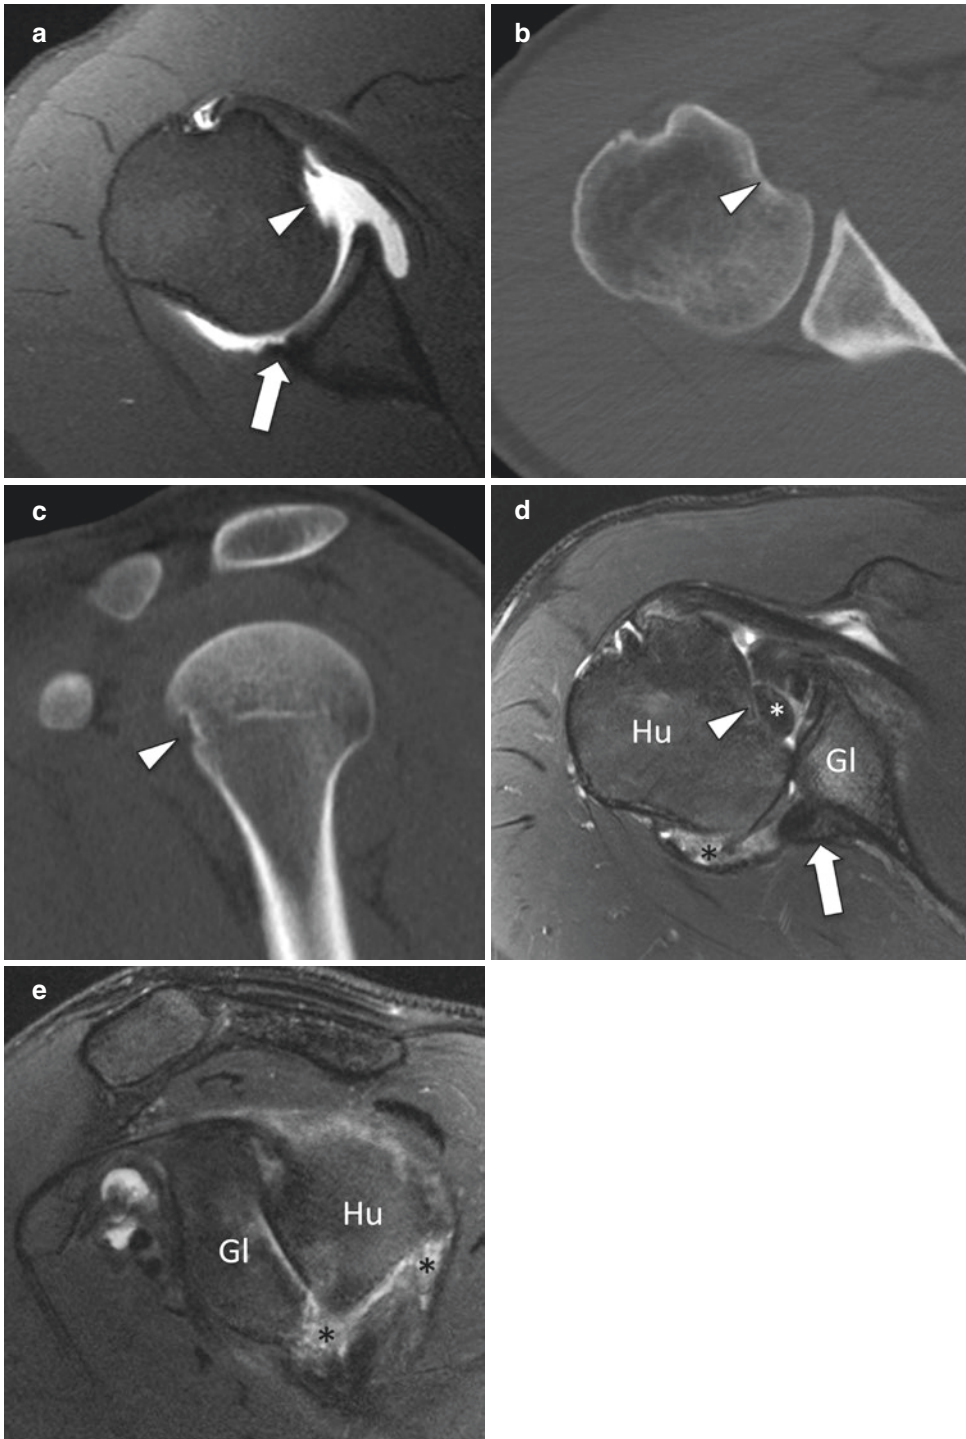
Posterior glenohumeral dislocation. Axial fat-saturated T1-weighted MR arthrographic image (a), and axial (b) and sagittal (c) CT reformats showing a reverse soft-tissue Bankart lesion (thick arrow) and a reverse Hill-Sachs fracture (arrowheads).
